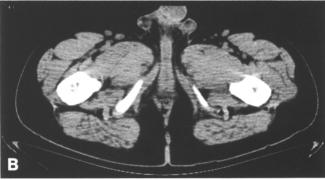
An example of adequacy (A) and deficiency (B) of the sphincter muscle complex (SMC) on postoperative CT scanning
